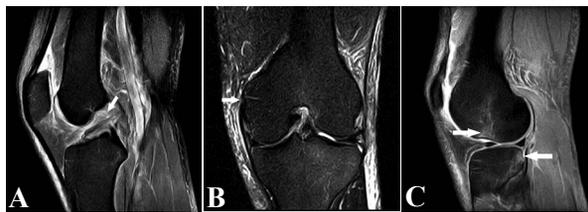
Magnetic resonance images of the left knee
